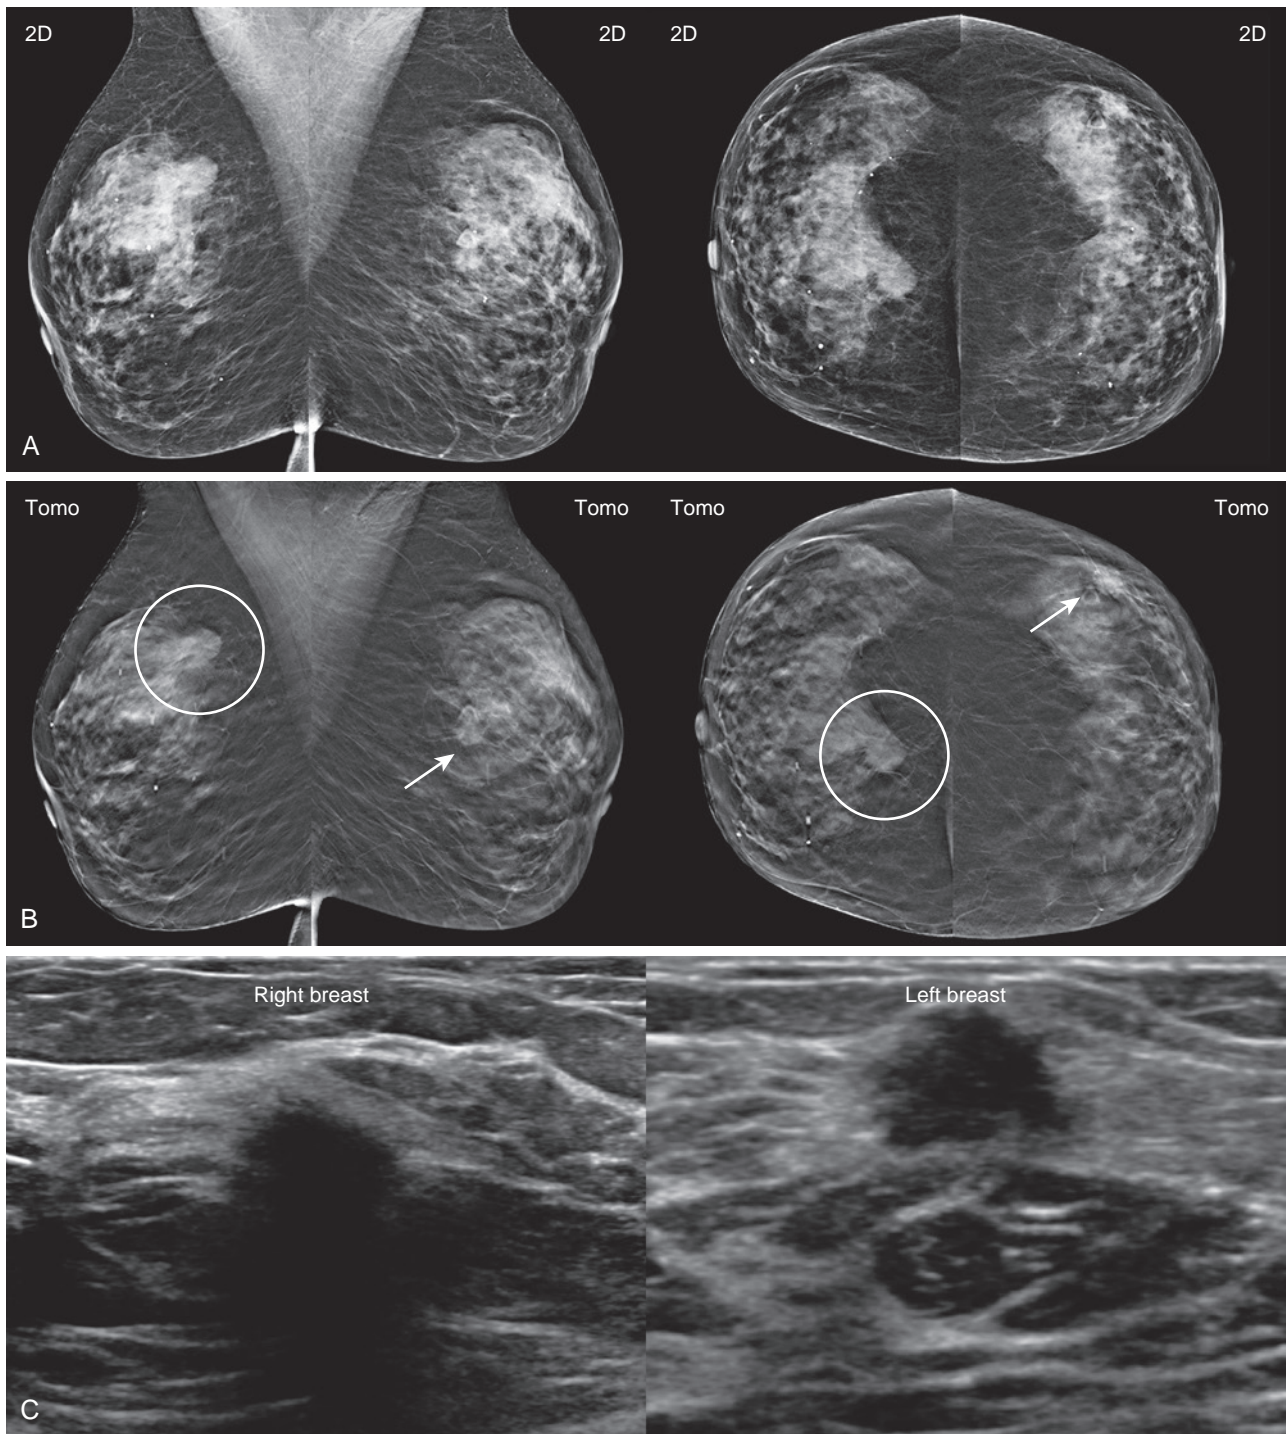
Avoid satisfaction of search. (A) A 69-year-old woman with heterogeneously dense breasts presents with a palpable finding in the lateral left breast (indicated by triangular skin marker). (B) A mass with spiculated margins corresponding to the palpable lump (*arrows*) is depicted well on the tomosynthesis slice images. However, an even larger irregular mass with spiculated margins (*circles*) is seen in the right breast 12-o'clock region. (C) Ultrasound reveals corresponding hypoechoic irregular masses bilaterally. Core biopsy of both masses showed invasive ductal carcinoma. Final surgical excision of the right breast mass showed Stage 2A, poorly differentiated triple negative carcinoma and Stage 1A ER/PR+, Her2 equivocal cancer of the left breast. Obvious findings in one breast should never preclude careful assessment of all areas of both breasts.
